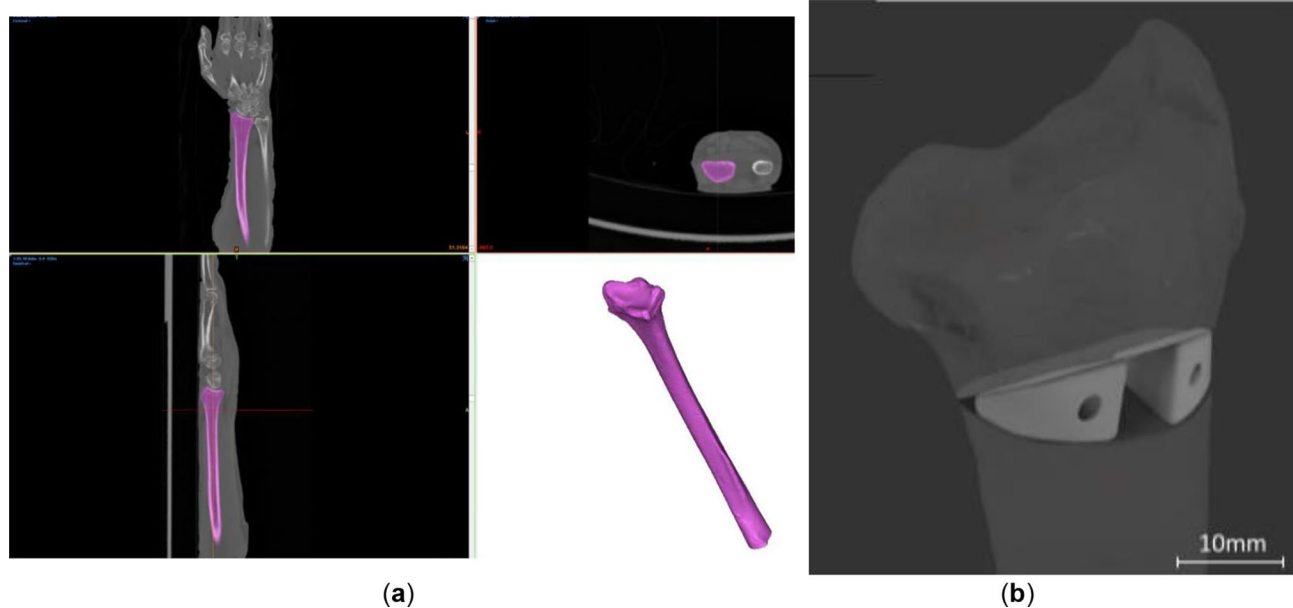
(a) Segmentation of the distal radius geometry based on the computed tomography data of the ex vivo sample SP (b) Virtual surgical plan of corrective osteotomy of the distal radius and implants for sample 1 L
